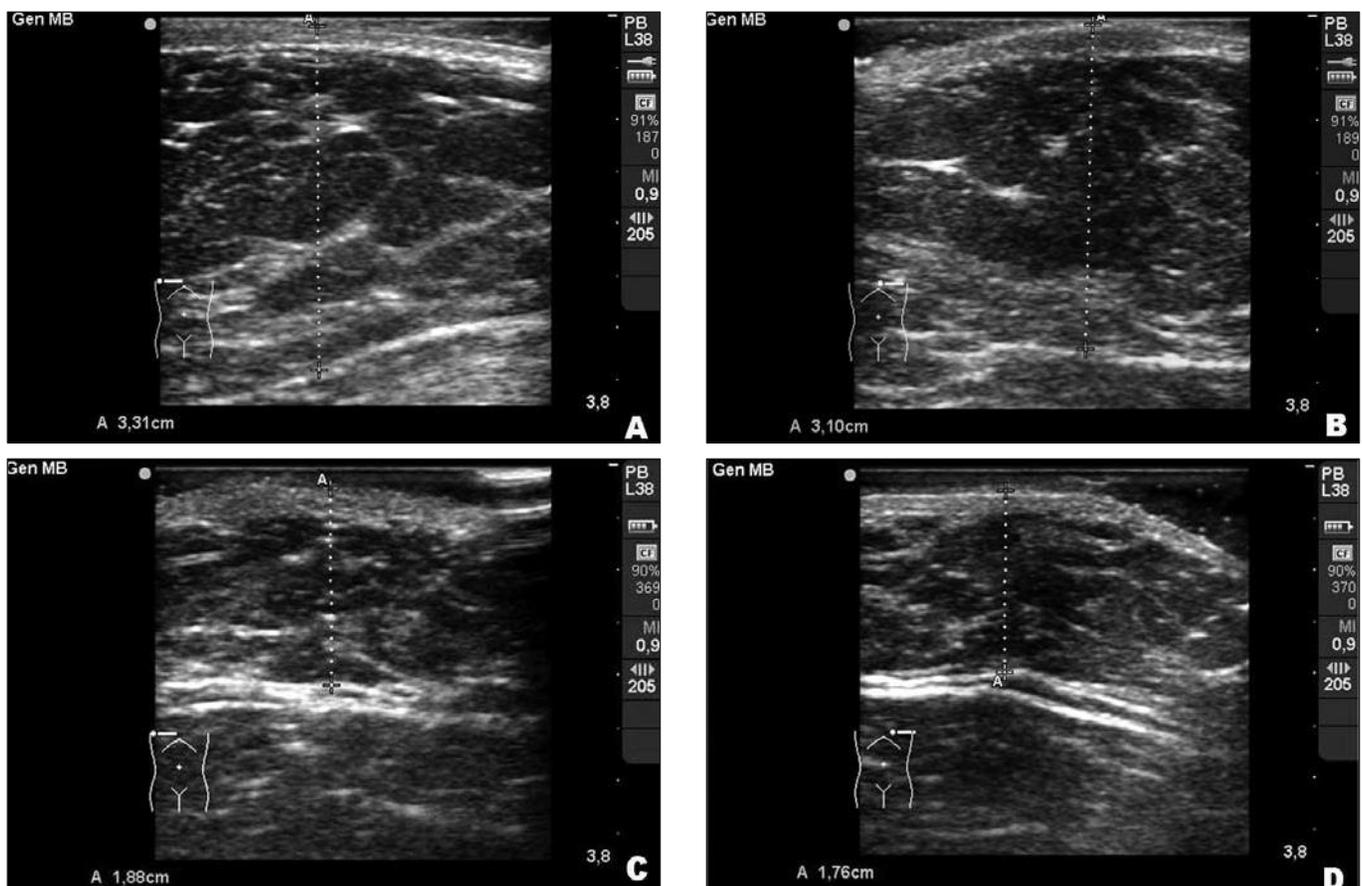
Ultrasonography of the patient of Figure 4. A. Right breast before laser lipolysis; B. Left breast before laser lipolysis; C. Right breast 6 months after the surgery; D. Left breast 6 months after surgery. In the ultrasonography tests of both breasts we can observe a remarkable decrease in the fat and an evident reorientation of the fibrous septa.
